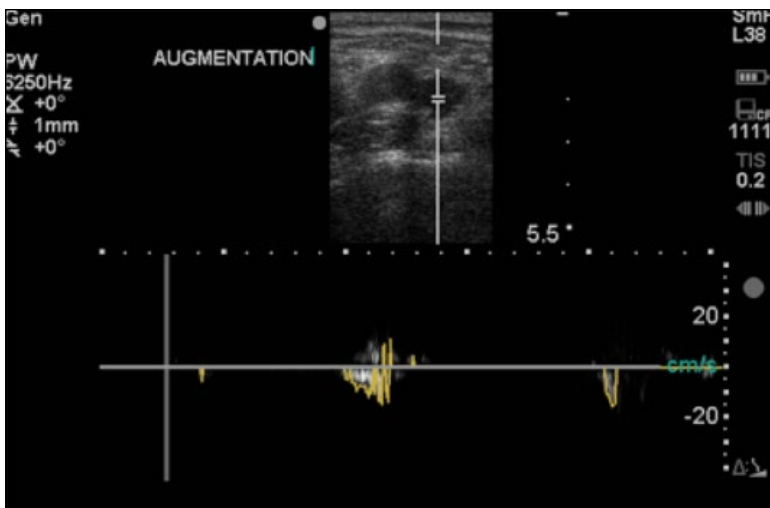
Normal augmentation using spectral Doppler mode.
